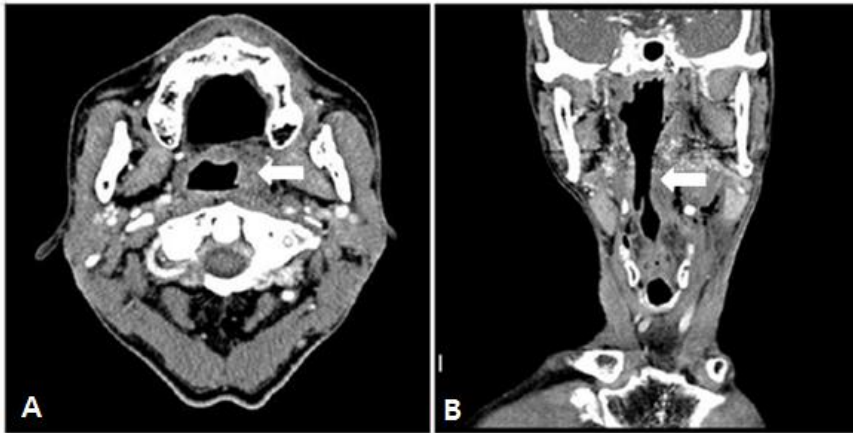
CT of the neck, transverse view (A), sagittal view (B) Neck CT showed irregular peripherally enhancing low density collection in lt. palatine tonsil and parapharyngeal space(arrow).
